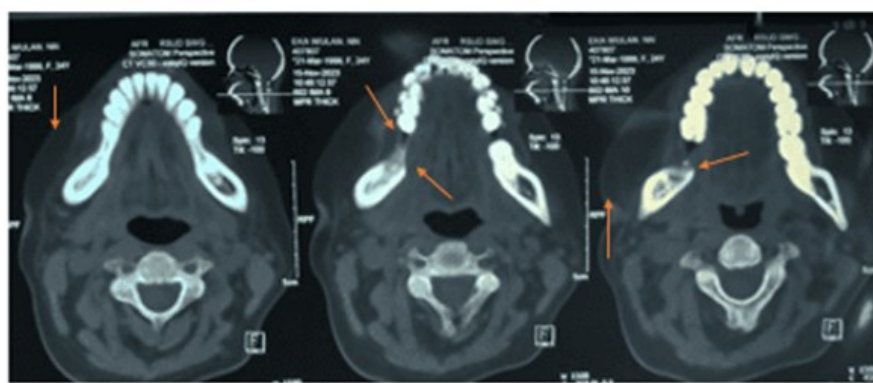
The axial CT scan corresponding to the OPG is shown in Figure 3 with a more detailed picture of osteolysis in the posterior side alveolar bone of the edentulous mandible dextra
